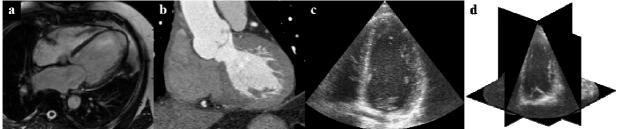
Examples of different cardiac imaging modalities: magnetic resonance imaging (a), computed tomography (b), 2-dimensional echocardiography (c) and 3D echocardiography (d). Computed tomography image courtesy of Walter Coudyzer, Department of Radiology, UZ Leuven, Belgium.
